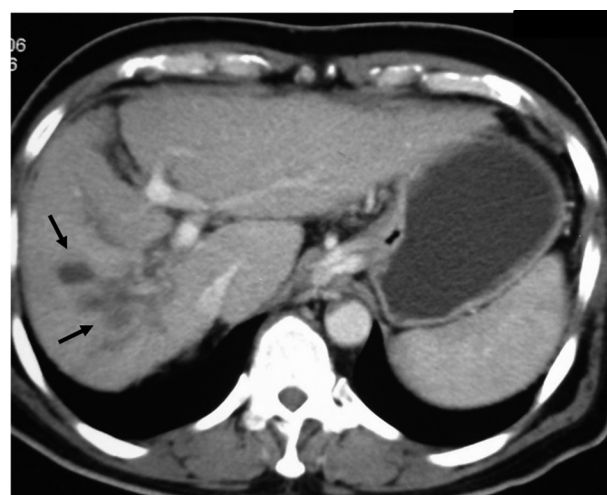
A 35-year-old man with HCC treated with TACE (patient 3). CT image in the axial plane obtained after intravenous administration of iodinated contrast material shows linear hypodensity suggestive of mild dilatation of the right hepatic duct (arrow).
